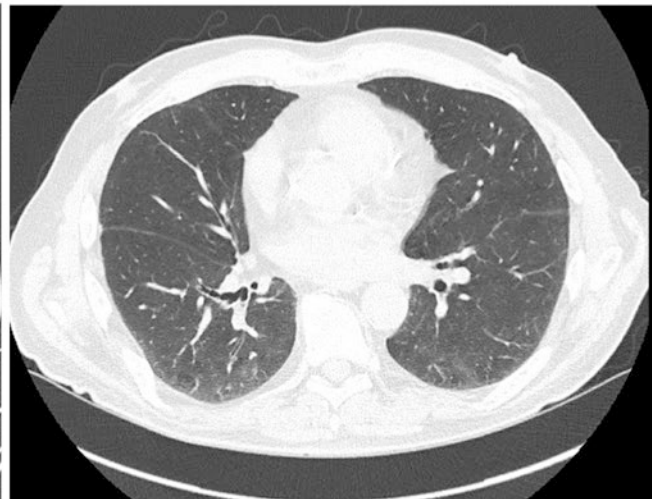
HRCT scan of the chest showing bilateral airway-based ground glass nodules with peripheral ground glass opacities representing alveolitis that completely resolved after treatment with steroids
